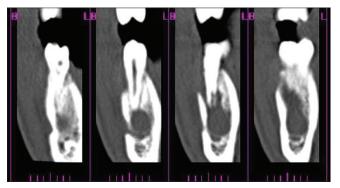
Spiral computed tomography scan (sagittal view) of left mandibular second premolar
